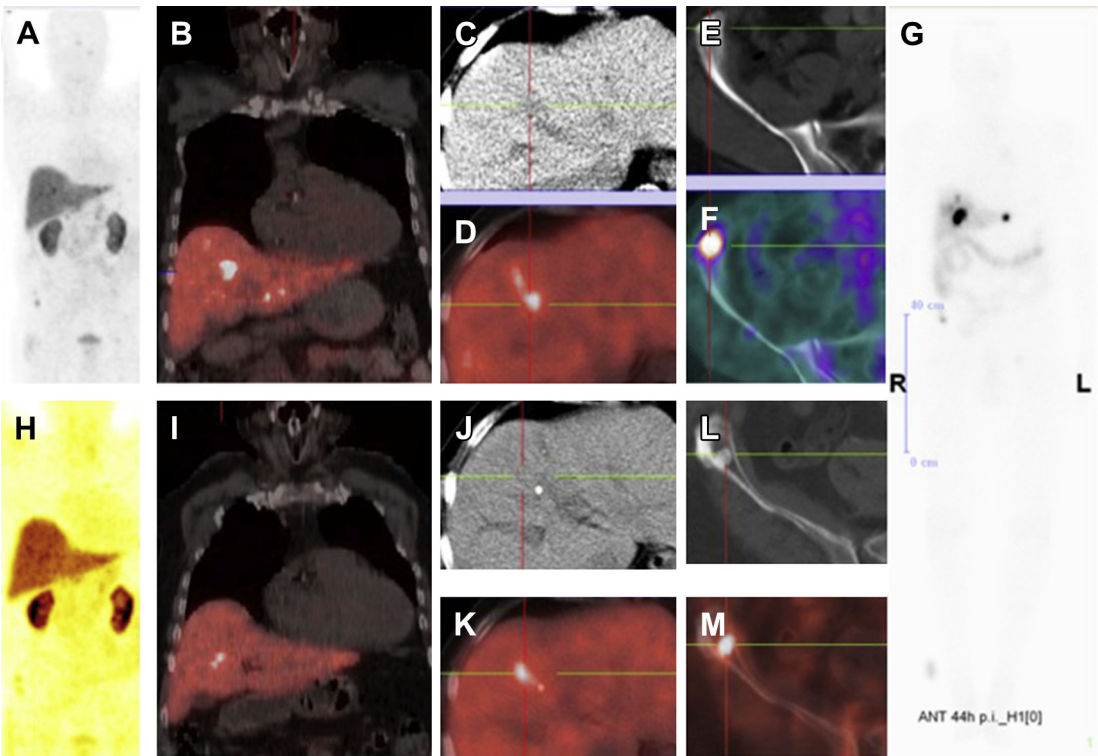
A 56-year-old man with well-differentiated, nonfunctioning ileal NET status post surgery and 2 cycles of PRRT with ^{90}Y -DOTATOC (performed elsewhere) with complete remission of the hepatic metastases thereafter was referred to the authors' center 5 years after the second PRRT cycle with progressive disease and development of hepatic and osseous metastases. He underwent 2 further cycles of PRRT with a total administered activity of 8 GBq ^{177}Lu -DOTATATE, resulting in a good response of the hepatic metastases (near-complete remission) and of the lesion in right iliac bone (partial remission). (A–F, ^{68}Ga -DOTATATE PET/CT images before therapy; G, ^{177}Lu -DOTATATE whole-body planar scan 44 hours post-PRRT1; H–M, ^{68}Ga -DOTATATE PET/CT images after 2 PRRT cycles; A and H, MIP; B and I, fused coronal images; C and J, transverse CT, and D and K, fused transverse PET/CT images of liver; E and L, transverse CT, and F and M, fused transverse PET/CT images showing metastasis in the right ilium).
